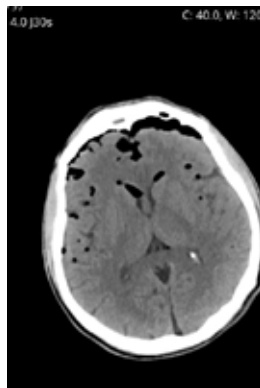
Axial brain CT showing multiple air bubbles seen diffusely throughout the brain subarachnoid spaces indicating pneumocephalus.
